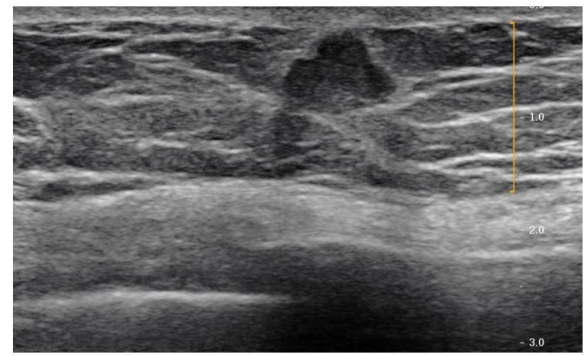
Grayscale ultrasound image of the left breast demonstrates a subareolar taller than wide irregular hypoechoic mass with lobular margins.
